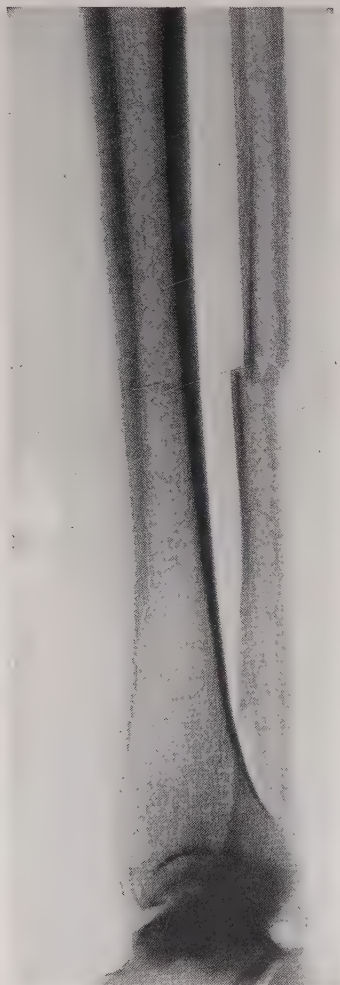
Roentgenogram of fracture of the fibula by direct violence. (Fracture Service, M. G. H.)
